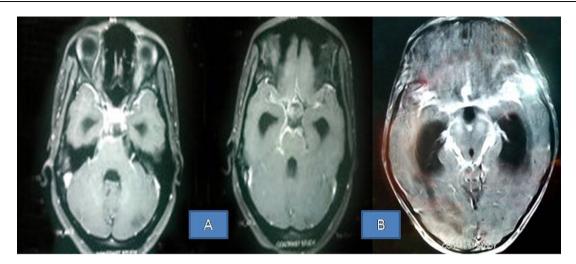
(A) Axial section of MRI brain T1 contrast study showing exudates across base of brain, optico-chiasmatic arachodinitis along with dialation of temporal horn of lateral ventricles, and fourth ventricle. (B) Axial section of MRI brain T1 contrast study showing basal exudautes encircling the brain stem ('spider web appearance') with hyperintesities in the mid brain area along with hydrocephalus.
